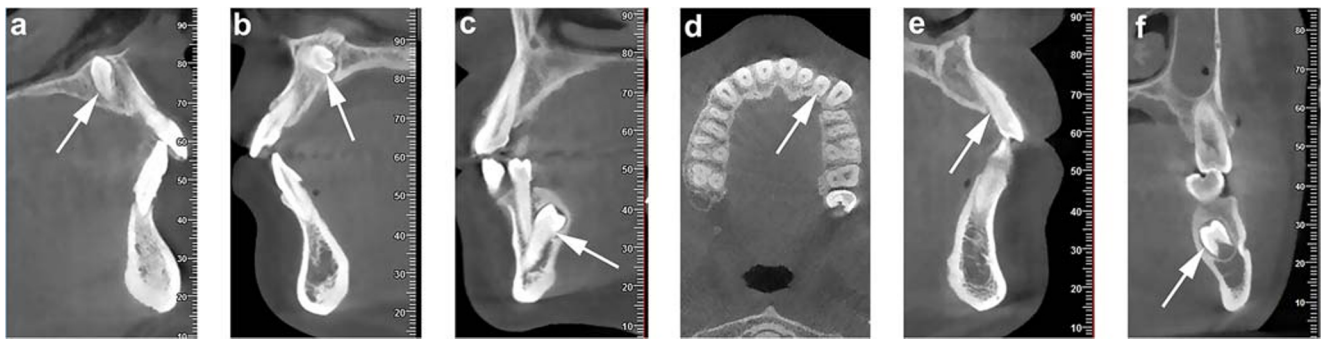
Representative CBCT images exhibiting morphology of ST. a conical morphology; b tuberculate morphology; c supplemental morphology of premolar; d supplemental morphology of lateral incisor
